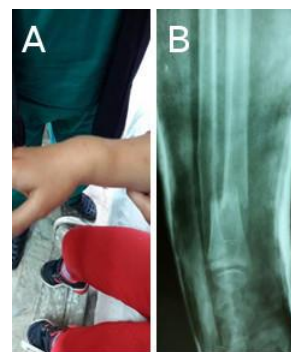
Photo of the presentation of the fracture (A) and an initial X-ray of the fracture (B)
